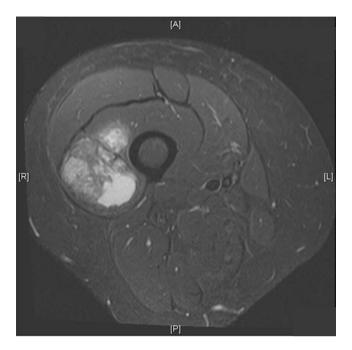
T2-weighted MRI image of a 7 cm right thigh fibromyxoid sarcoma
